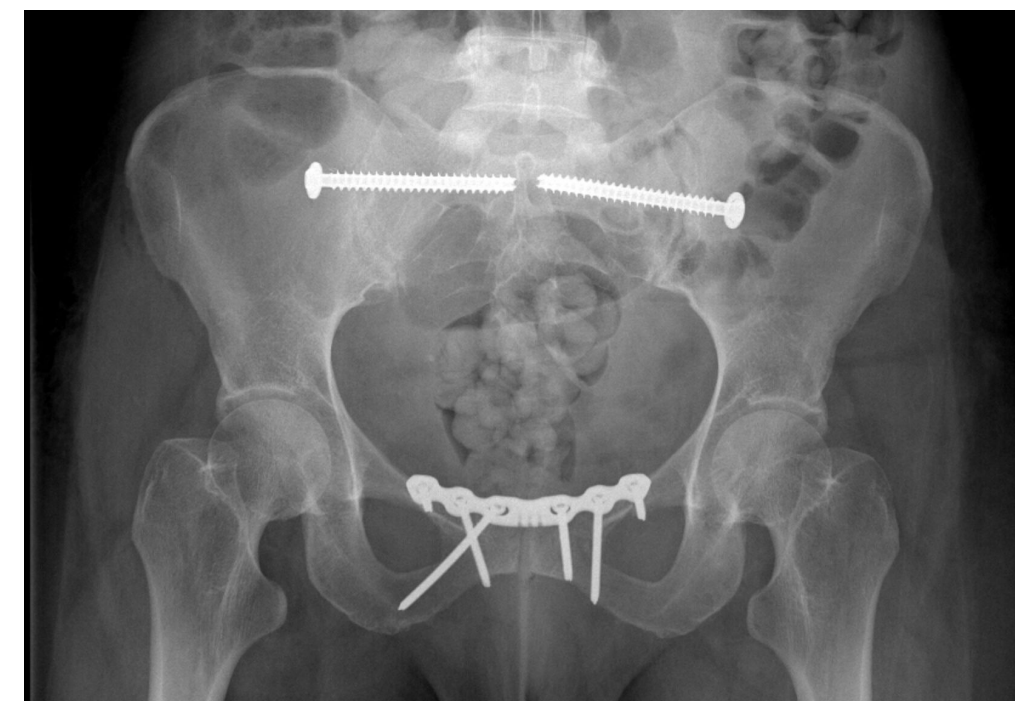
Pelvic x-ray showed internal fixation of the bilateral sacroiliac joints and pubic symphysis.
